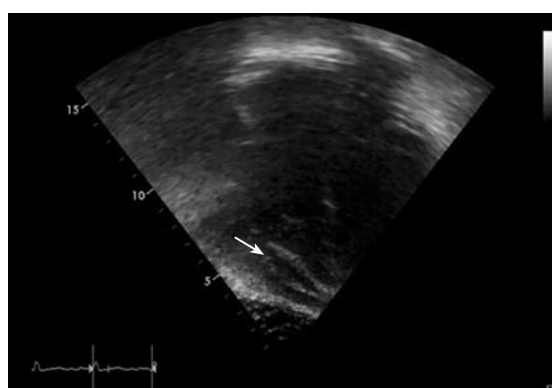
Echocardiogram-4-chamber view showing pericardial effusion (arrow).
